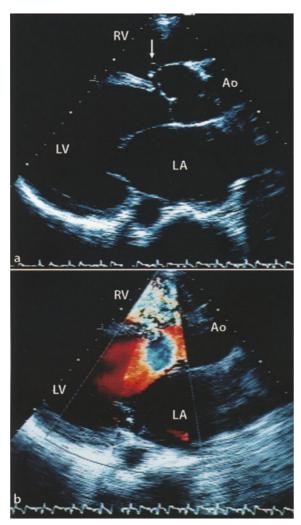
Aneurysm of Valsalva: a preoperative transthoracic echocardiography, showing the ruptured aneurysm of the right sinus of Valsalva (arrow) protruding into the right ventricle through a large ventricular septal defect, b preoperative transthoracic Doppler echocardiography of the same patient, showing the severe regurgitation into the left ventricle from the ruptured aneurysm of the right sinus of Valsalva and the left-toright shunt through the ventricular septal defect (*Ao* aorta, *LA* left atrium, *LV* left ventricle, *RV* right ventricle)
